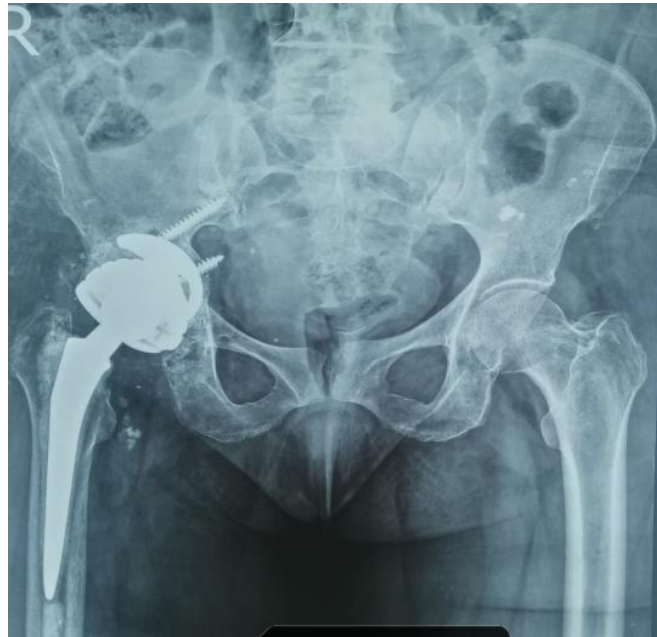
follow up x-ray after 3 months
